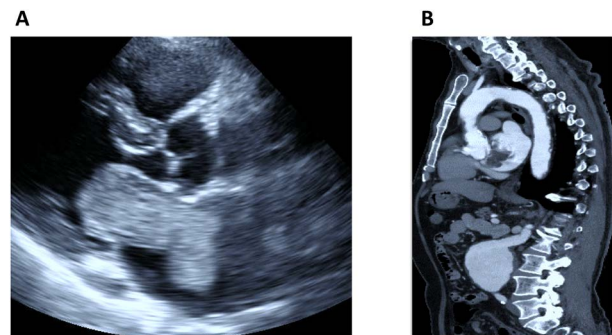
(A) Transthoracic echocardiography showed a left atrial myxoma prolapsing through the mitral valve during diastole. (B) Computed tomography demonstrated the site and extent of the atheroma in the proximal aorta and infra-renal abdominal aortic aneurysm.
